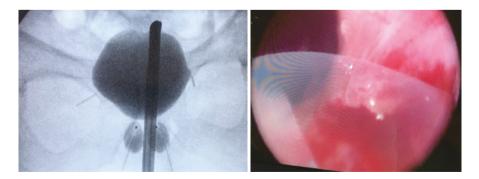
Urethral perforation: X-ray and corresponding endoscopic view
